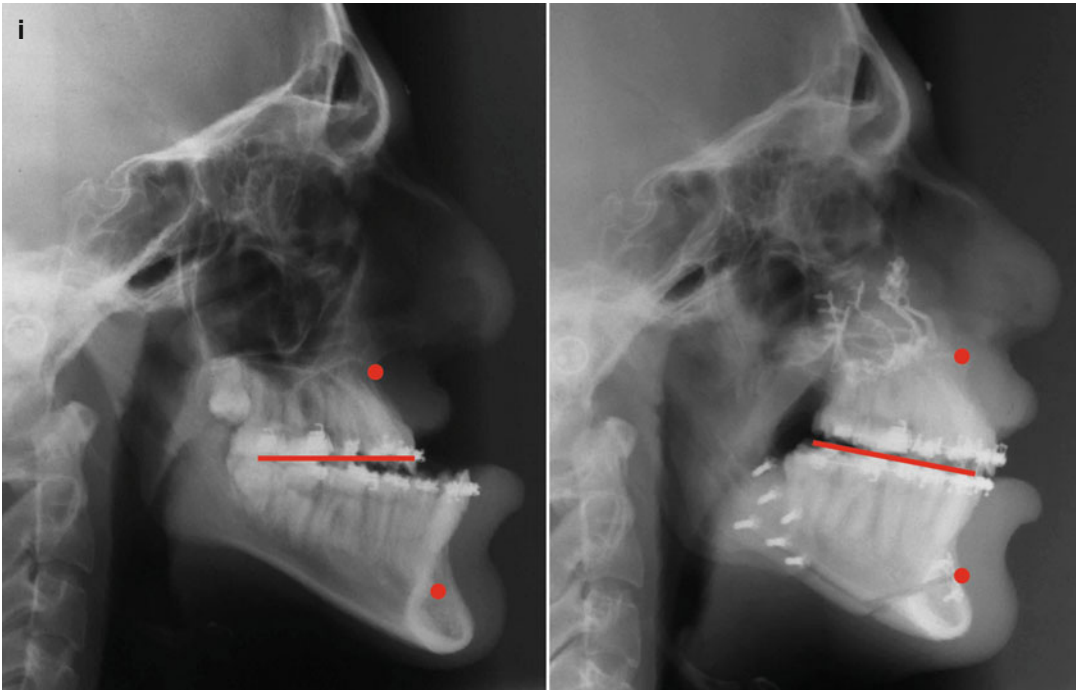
(continued) (i) Lateral Cephalometric radiographs before and after reconstruction
